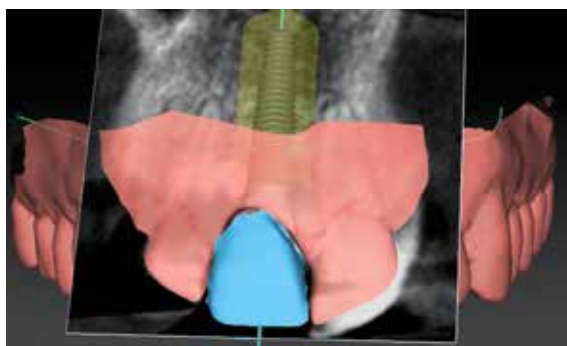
Three-dimensional visualisation of the patient surface anatomy, tooth design, implant positioning and the related CBCT cross-section in accordance with the ideal gingival margin, papilla height and prosthetic emergence.
